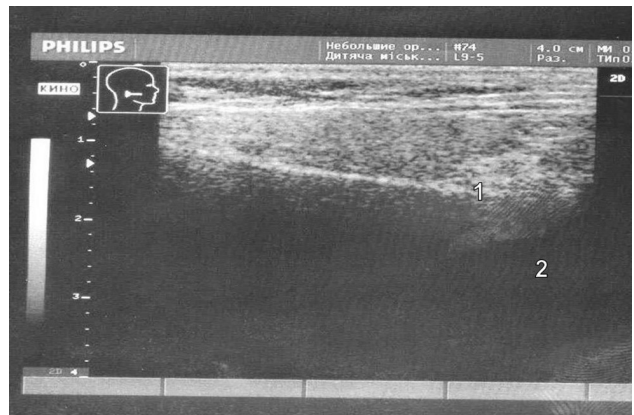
Ultrasound image of the right parotid gland. The image shows a single small sialectases (1) and compaction of parenchymal tissues (2)
